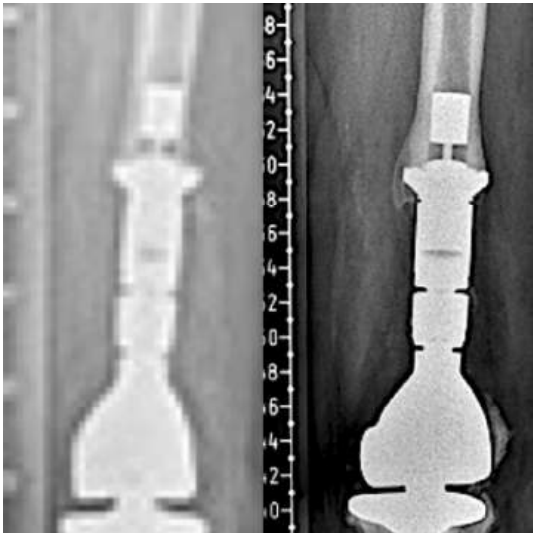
An AP radiograph (case #13) reveals bone hypertrophy in the interface host bone–implant which indicates a scoring of 3 points according to the Groundland radiographic scale
